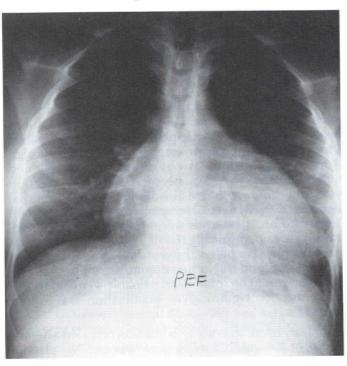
Chest radiograph indicating enlarged heart.
